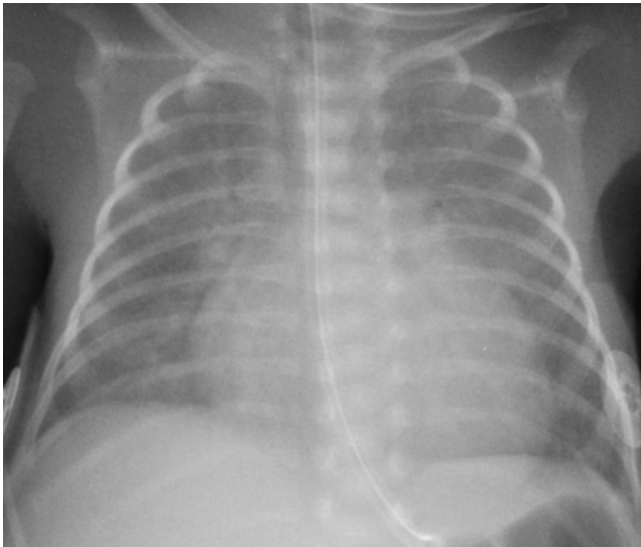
Chest radiograph of a patient with a large PDA demonstrates cardiomegaly and pulmonary edema. *PDA* patent ductus arteriosus
